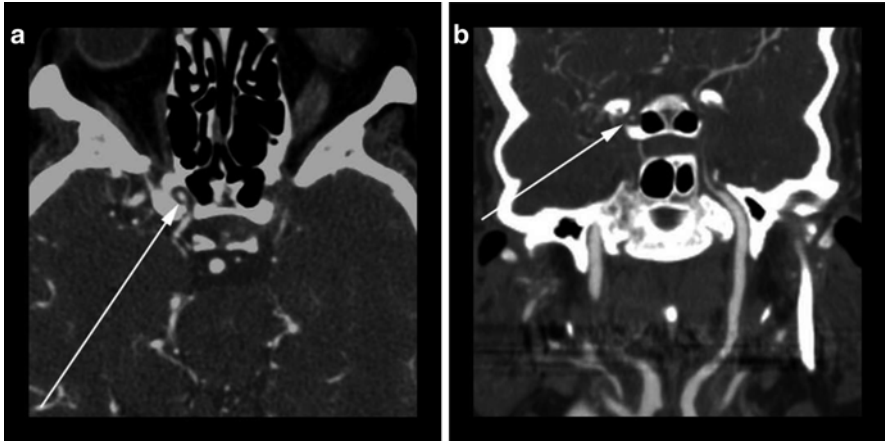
75-year-old female with chronic headaches and transient ischemic attack. (a) Axial CTA image shows moderate stenosis of the anterior genu of the right cavernous segment (*arrow*) of the internal carotid artery and critical stenosis of the left internal carotid artery at the same level. (b) Coronal oriented curved MPR CTA image depicts the long segment abnormality (*arrow*) involving the distal left internal carotid artery
